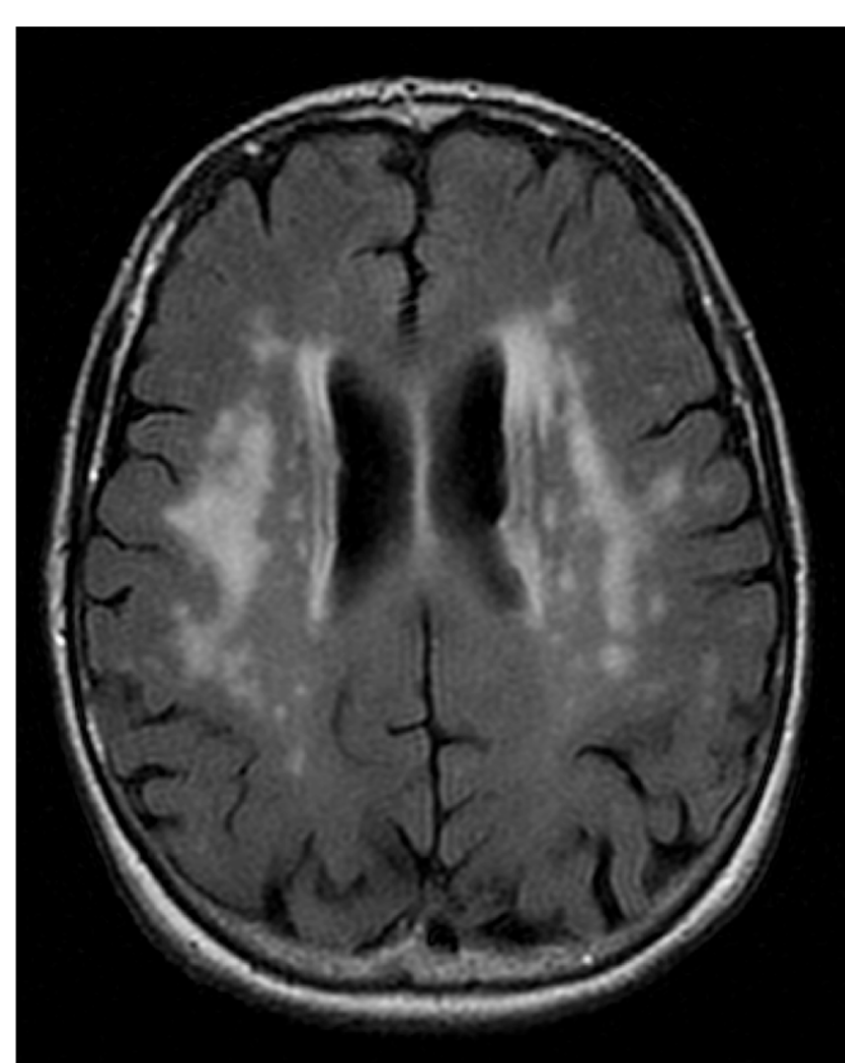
Axial FLAIR MRI showing more marked Hyperintensity burden.
